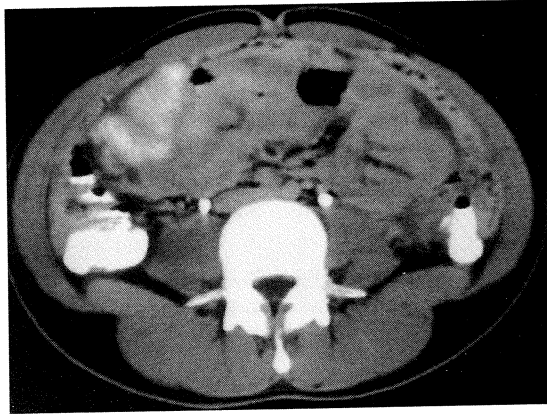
CT scan: Thickening and infiltration of bowel and mesentery.
